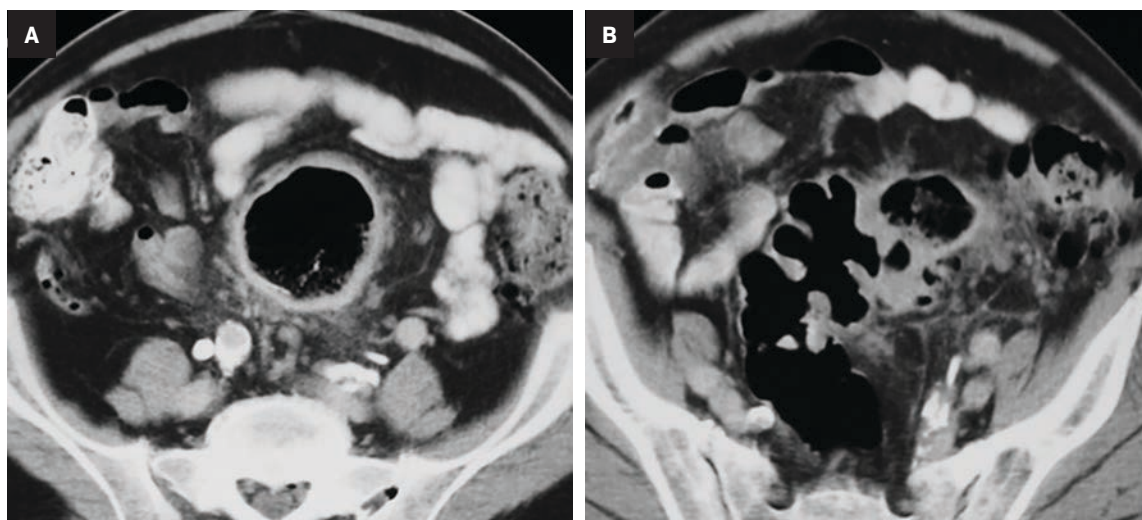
Interventional radiologic management of GSD in an adult. (A) CT shows a 6 cm cystic lesion with 2-mm-thick walls, containing gas and fluid. The adjacent mesenteric fat has vascular engorgement and edema due to inflammation. (B) CT-guided placement of a pigtail catheter into the lesion. External drainage led to its gradual collapse. (C) CT performed 2 months later shows reduced size of the GSD to about 2 cm (arrow), which resolved on follow-up studies.
